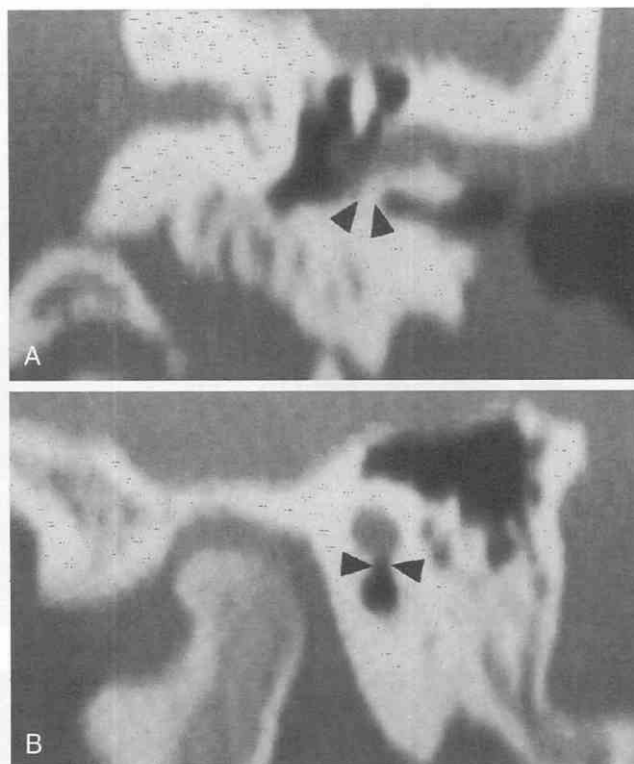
Osteoma of the left external auditory canal (EAC) in a 13-year-old boy with a history of cold-water swimming and a chronic deformity of the EAC. Coronal (A) and sagittal (B) reformatted CT images through the left EAC. The EAC is opacified, with osseous constriction of its medial portion. The osteoma (arrowheads) is completely incorporated into the adjacent bone (A). Note the keyhole constriction (arrowheads) of the EAC, best seen in the sagittal reformatted image (B). Within the stenotic EAC is a soft tissue mass that represents a secondary EAC cholesteatoma.
